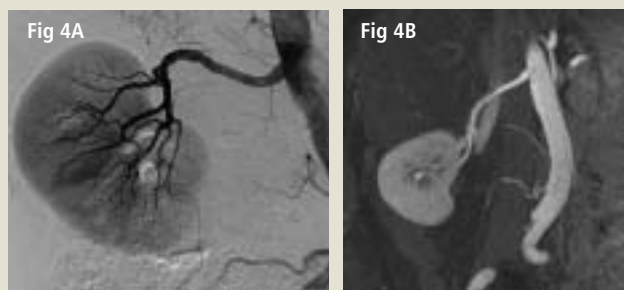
(a+b): Conventional renal angiogram (a) and corresponding 3-D high-resolution contrast-enhanced MR angiographic oblique maximum intensity projection (MIP) (b) from a female patient with fibromuscular dysplasia of the right renal artery. This is evidenced by beading and irregularity of the distal third of this vessel on both imaging techniques. While of inferior spatial resolution to conventional radiographic techniques, CE-MRA at 3 Tesla maintains high diagnostic accuracy, while precluding the requirement for arterial puncture and ionising radiation exposure.
